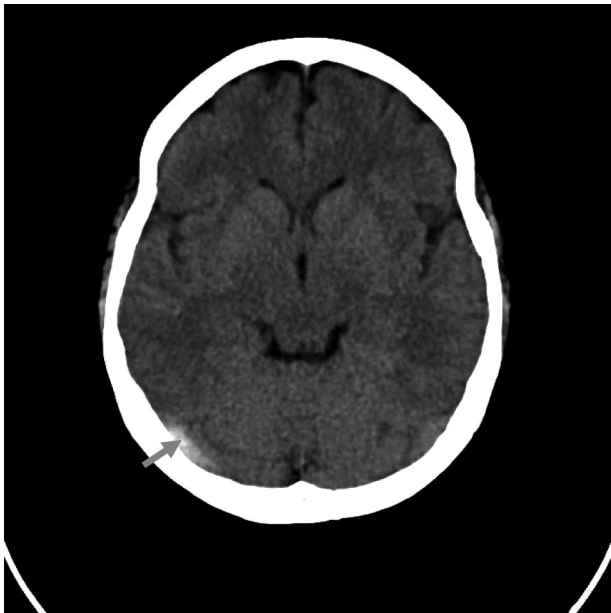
Noncontrast computed tomography head scan showed spontaneous hyperdensity of right transverse sinus.
